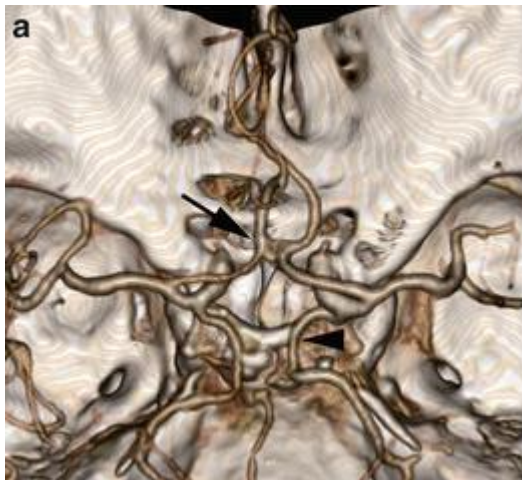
3D CT angiogram of the circle of Willis. Arrow points to fenestrated anterior communicating artery. Bilateral fetal Posterior cerebral arteries are also demonstrated (arrowhead). Image courtesy of postern.netkey.at
